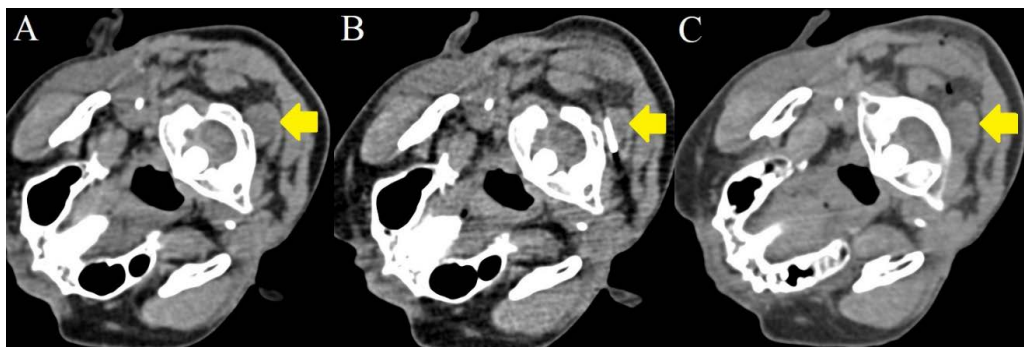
CT images of a 54 year-old lady with tenosynovial giant cell tumor at the upper cervical spine, likely arising from the posterior atlantoaxial membrane.
